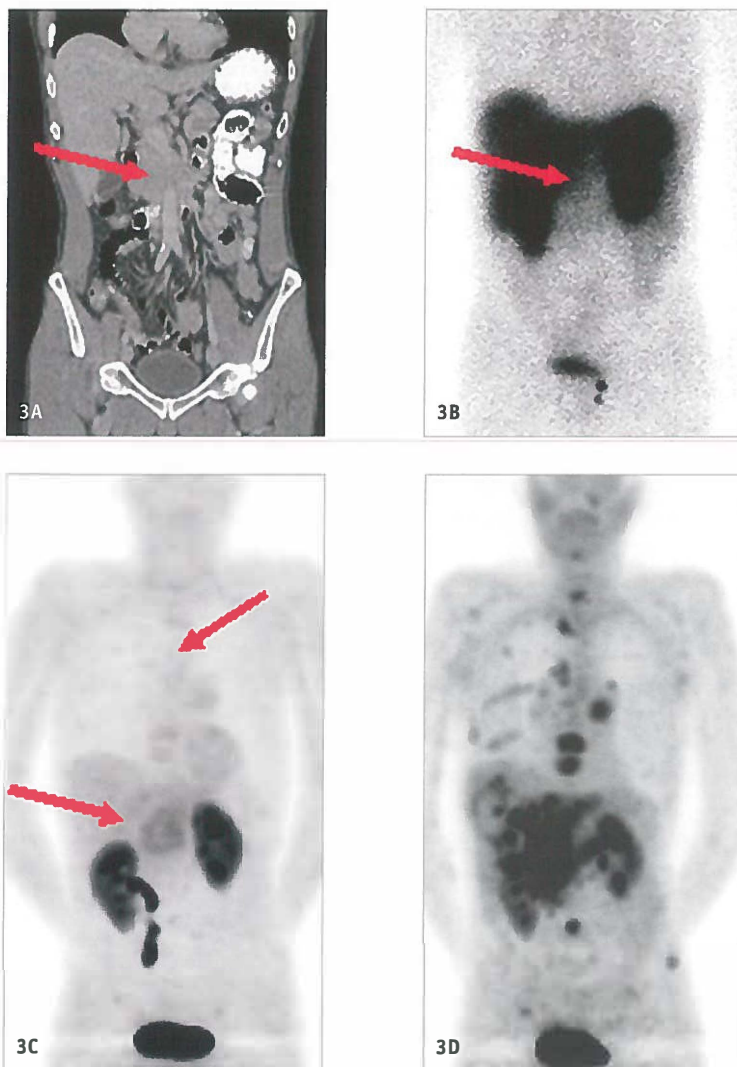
CT scan (A), SRS (B), ^{18}F -DOPA PET (C) and ^{11}C -5-HTP PET (D) of a 54 year old male patient with metastatic islet cell tumour.
